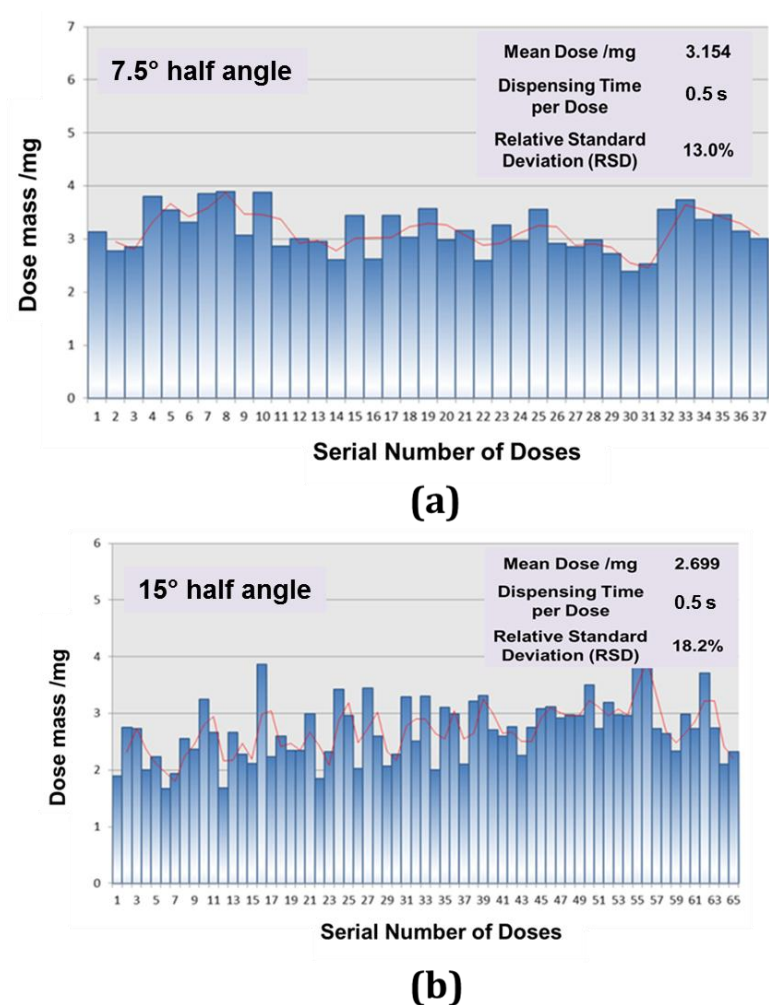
17 Evaluation chart of ultrasonic dispensing of starch with conical angle (a) 7.5° and (b) 15° . Orifice size: 1.0 mm; duration of vibration: 0.5s
